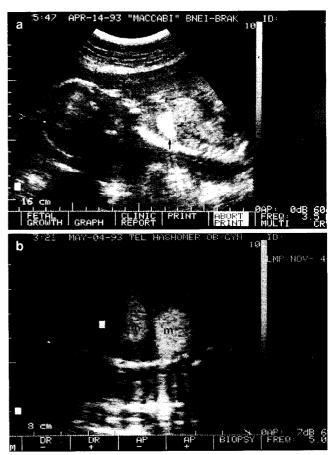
Prenatal ultrasound scan at 21 weeks' gestation of longitudinal section through fetal thorax (a). Note hyperechogenicity at the right lower lobe (arrows). Oblique transverse scan (b) in another case shows two echogenic masses (m) occupying the lower and middle lobe of the right lung
